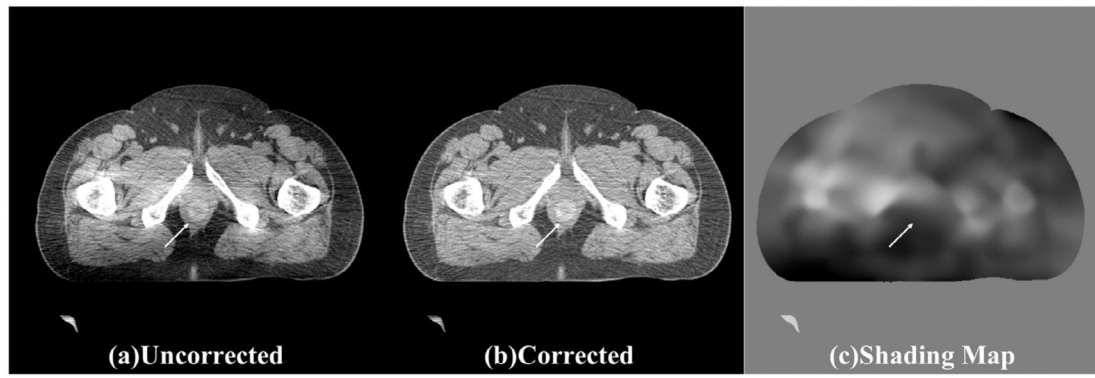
Shading correction results for the case of a manually inserted tumor with spatially-varying CT numbers. (a) uncorrected CBCT, (b) corrected CBCT, and (c) shading map obtained using the proposed algorithm.
